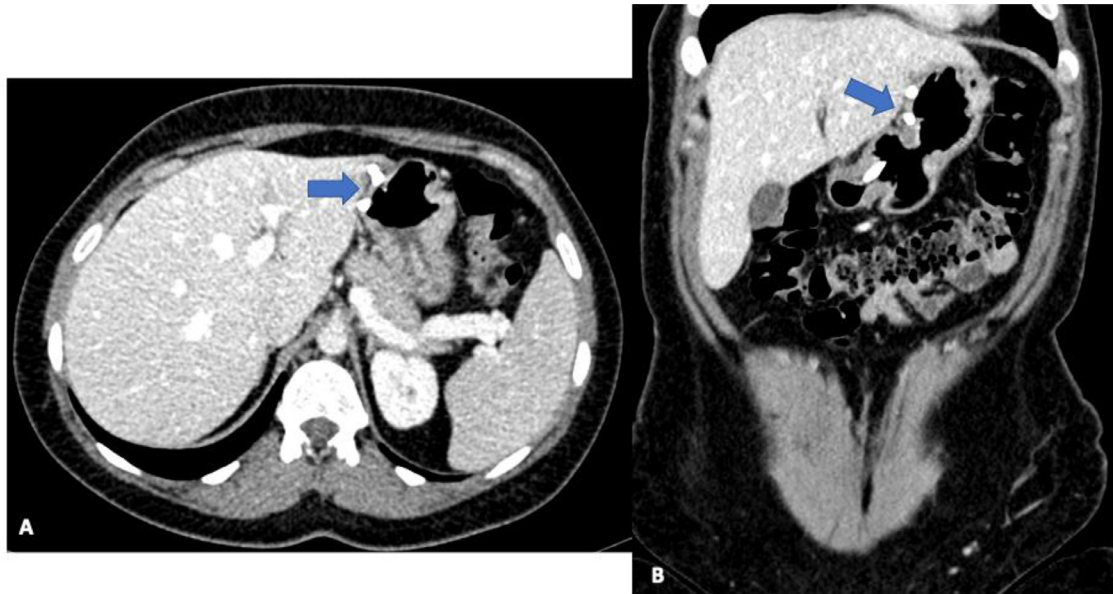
Axial (A) and coronal (B) contrast-enhanced abdominal CT performed 2 months after endoscopic drainage, showing complete disappearance of the abscess (blue arrows).
